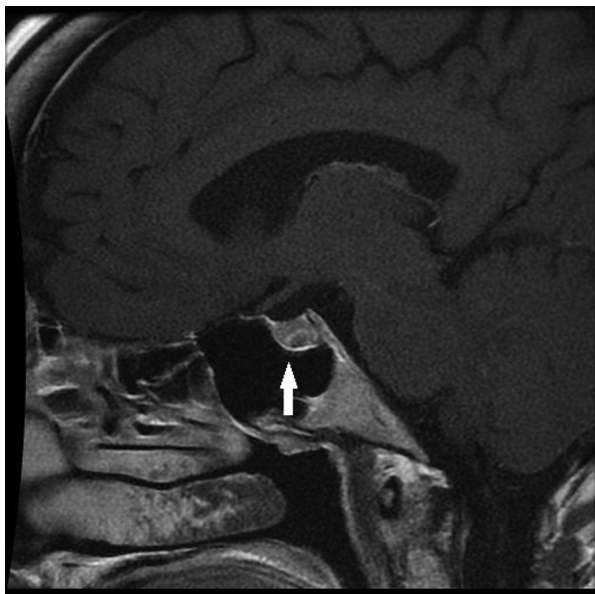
Pituitary MRI showing a 5 mm pituitary lesion (arrow).
